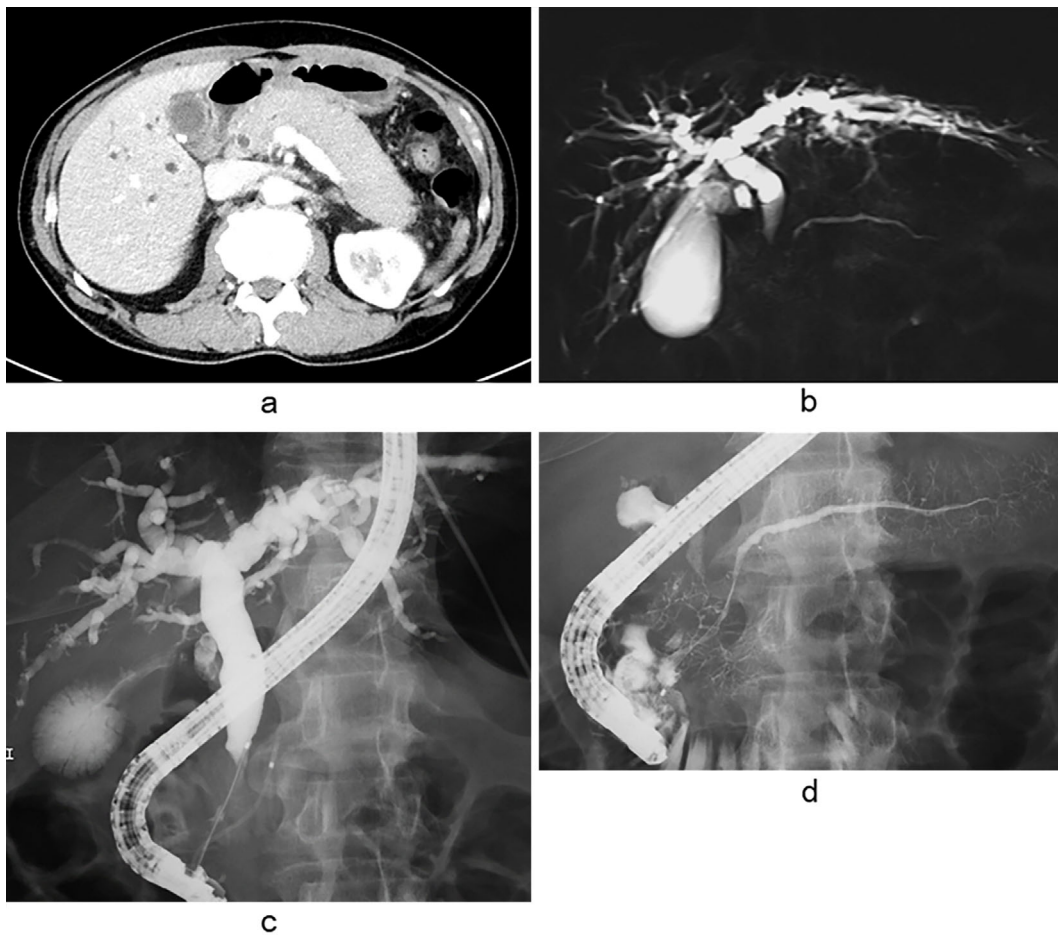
Images obtained before treatment. (a) Computed tomography (CT) shows a bulky pancreas with a capsule-like rim without dilation of the pancreatic duct. (b) Magnetic resonance cholangiopancreatography (MRCP) shows a distal stricture of the common bile duct with dilation of the upstream bile duct. The main pancreatic duct of the pancreatic head is not detected. (c, d) Endoscopic retrograde cholangiopancreatography (ERCP) shows a distal stricture of the common bile duct with dilation of the upstream bile duct and segmental constriction of the main pancreatic duct at the head of the pancreas. The pancreatic duct at the tail side is not dilated.
